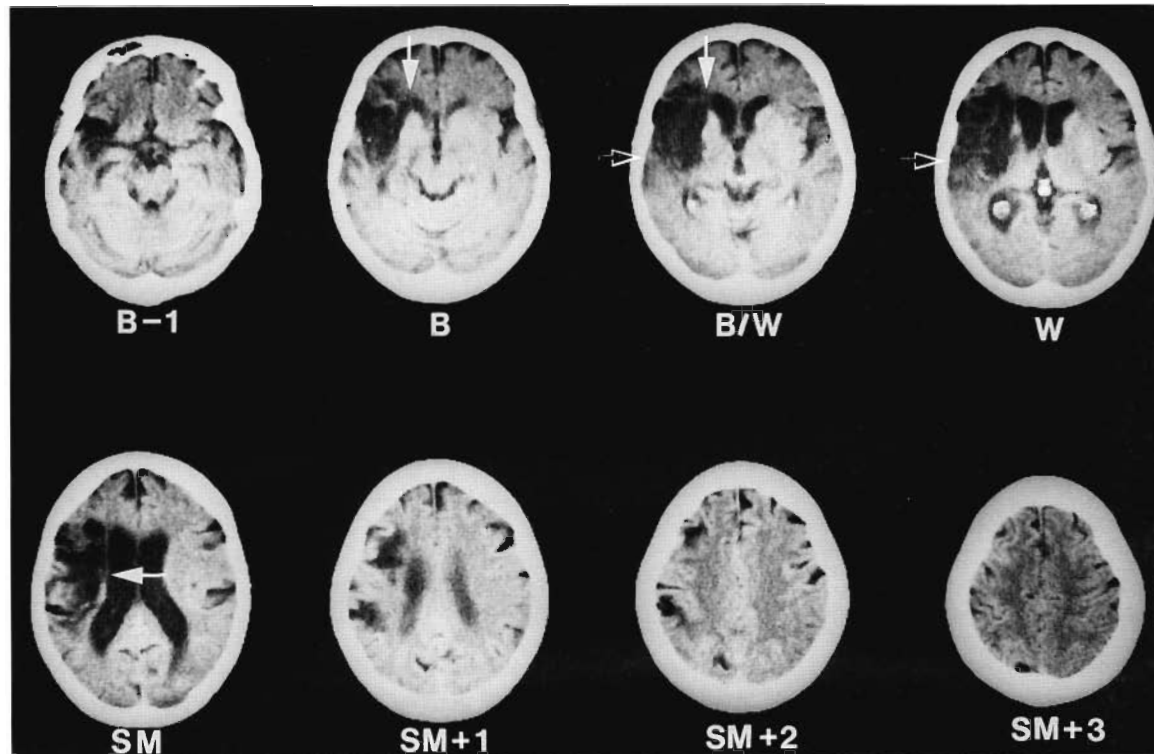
CT scan for patient SH, a 65-year-old woman, who entered the C-ViC program at 4 MPO and had good response to the C-ViC treatment program. The basic lesion site pattern associated with no recovery of spontaneous speech was present in the medial ScF area on slices B and B/W (white arrows), plus the M $\frac{1}{3}$ PVWM area on slice SM (white arrow). The total extent-of-lesion rating for medial ScF area plus M $\frac{1}{3}$ PVWM area was 9.65. In addition, extensive lesion was present in only *one* of the two extra areas. Lesion was present in the temporal lobe area, including Wernicke's area on slices B/W and W (black and white arrows) and the subcortical temporal isthmus area on slices B-1 and B. No lesion was present in the supraventricular area, including the SMA and cingulate gyrus on slices SM + 2 and SM + 3. The CT scan was done 6 MPO.
